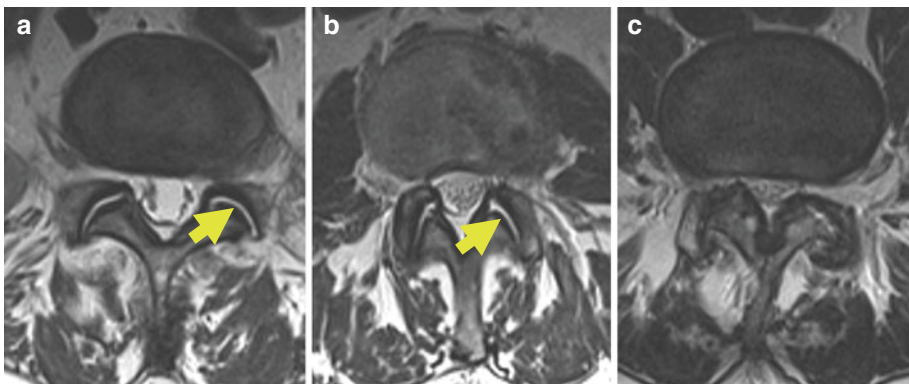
Axial T2-weighted imaging of the lumbar spine. In (a), there is mild facet hypertrophy, while in (b), there is increased hypertrophy and impingement compatible with moderate facet hypertrophy. In (c), the facet
